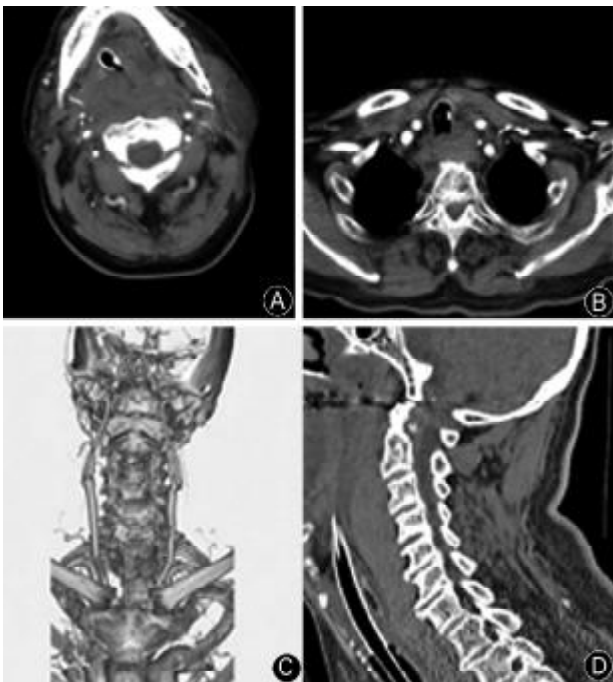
A, B: Cervicothoracic CT with contrast medium (axial imaging) revealed a massive hematoma extending from the retropharyngeal to the superior mediastinal space and showed no evidence of contrast medium extravasation or a vertebral fracture. C: CT angiography revealed no major vascular injury. D: Reconstructive sagittal CT revealed a massive retropharyngeal hematoma and no evidence of a vertebral fracture.
